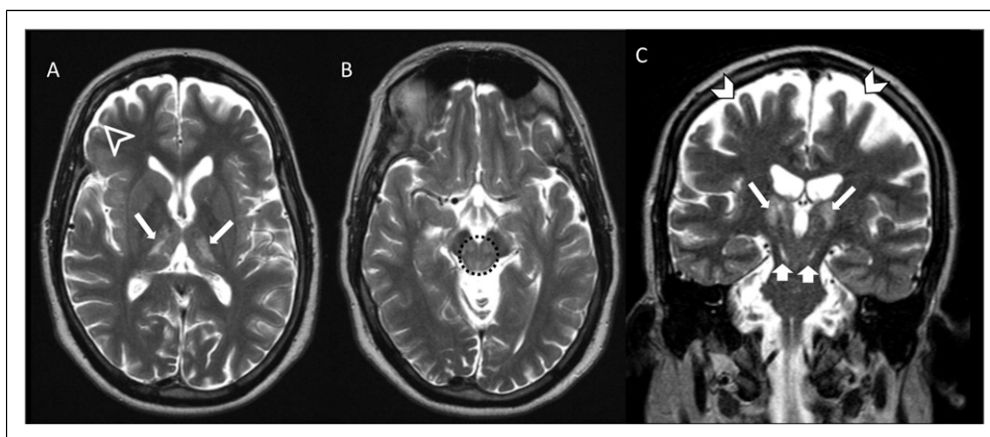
51-year-old man presented with a 22-year history of recurrent behavioral changes and epilepsy. A. Axial T2-weighted image shows thalamus lesions (arrows) and right frontal juxtacortical hyperintensity (arrowhead). B. Axial T2-weighted image shows hyperintensity in the mesencephalic tegmentum compromising red nuclei and inferior colliculi (circle). C. Coronal T2-weighted image shows hyperintensity in the thalami (long arrows) the dentatothalamic tract (short arrows) and volume loss in the frontal lobes (arrowheads).
